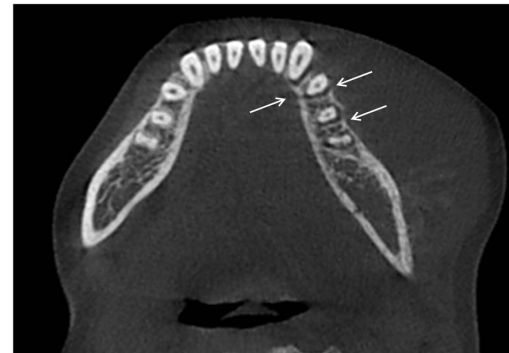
Axial CBCT view showing, multiple tiny perforation of buccal and lingual cortex in the area of lesion.
